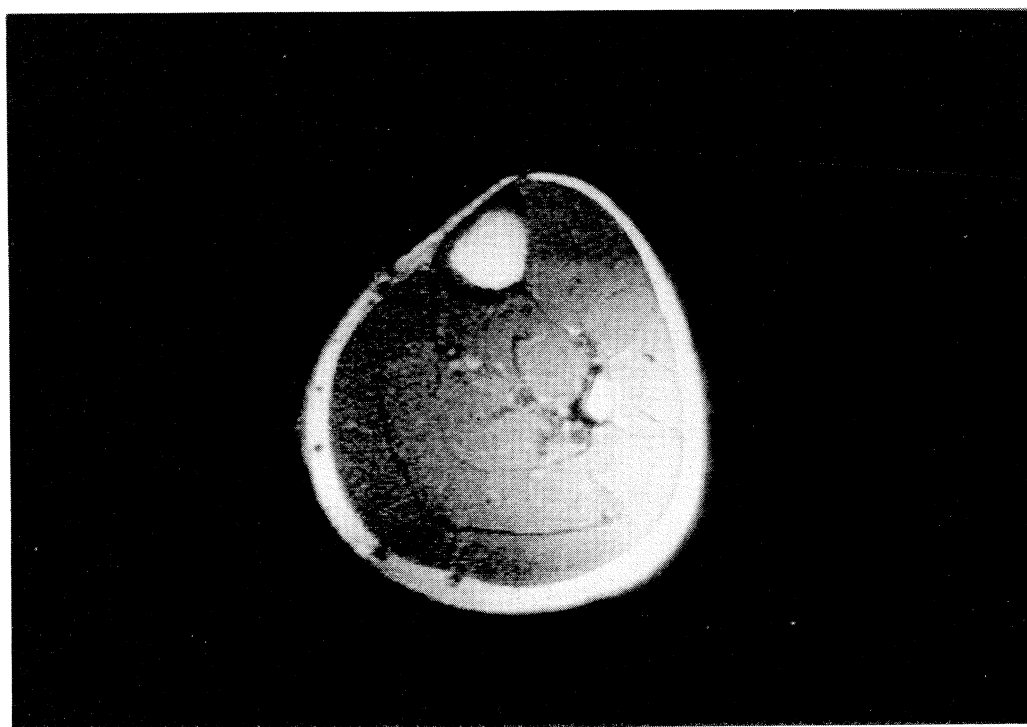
MR image of a calf from an 11 year old healthy boy. Note the homogeneous gray color of muscles and the absence of fatty tissue between individual muscles.
